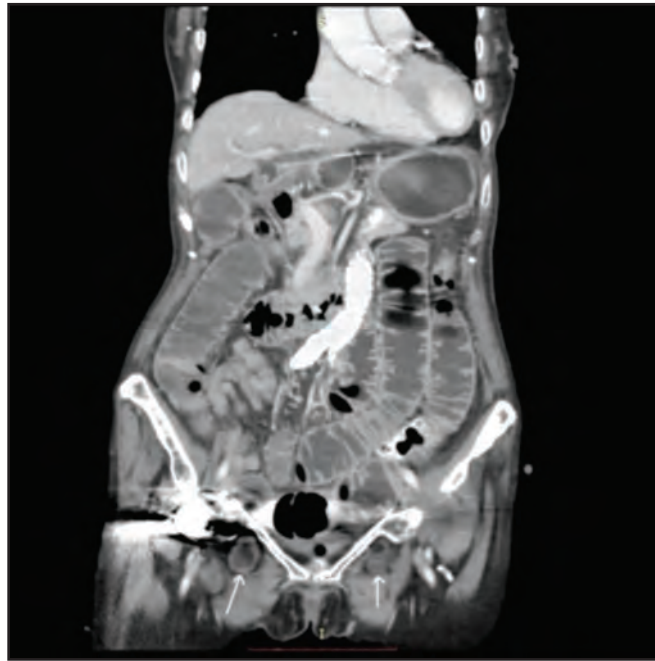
CT abdomen and pelvis with contrast coronal view shows right and left obturator hernia containing fluid-filled short segment non-dilated small intestines (white arrows), with small intestine dilatation and artifact from right hip implant seen.
